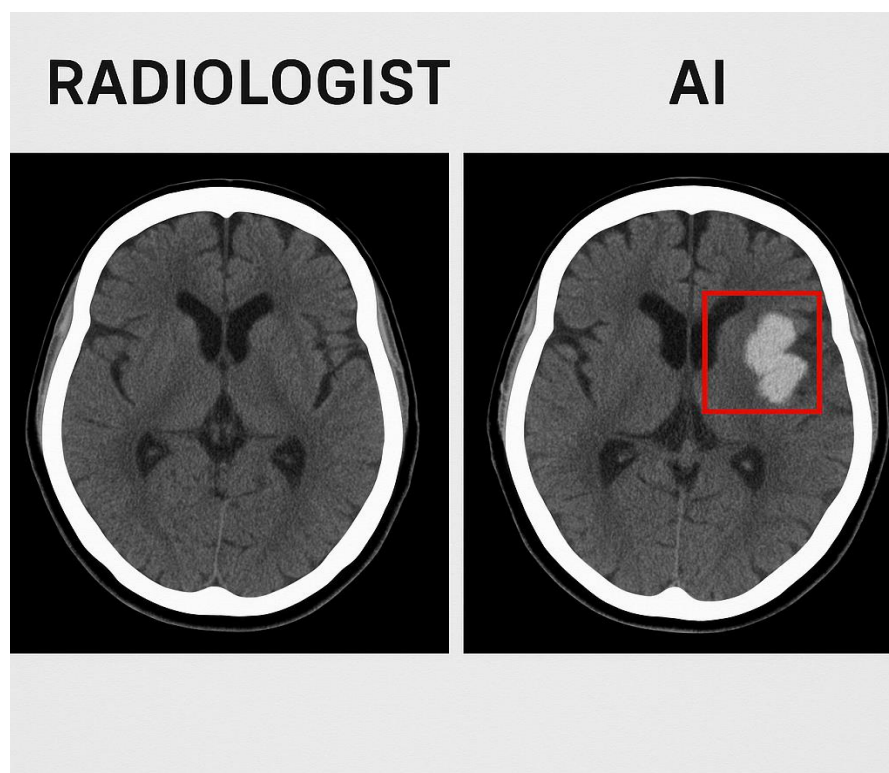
Comparison of standard radiologist interpretation (left) and AI-augmented CT scan (right), with AI highlighting a suspected abnormality.
